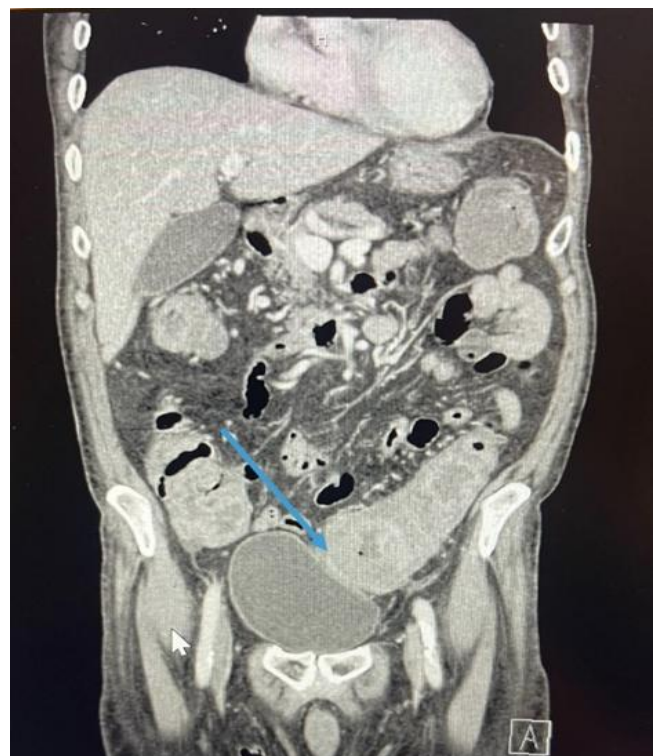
Follow-up CT scan two weeks post-discharge.
